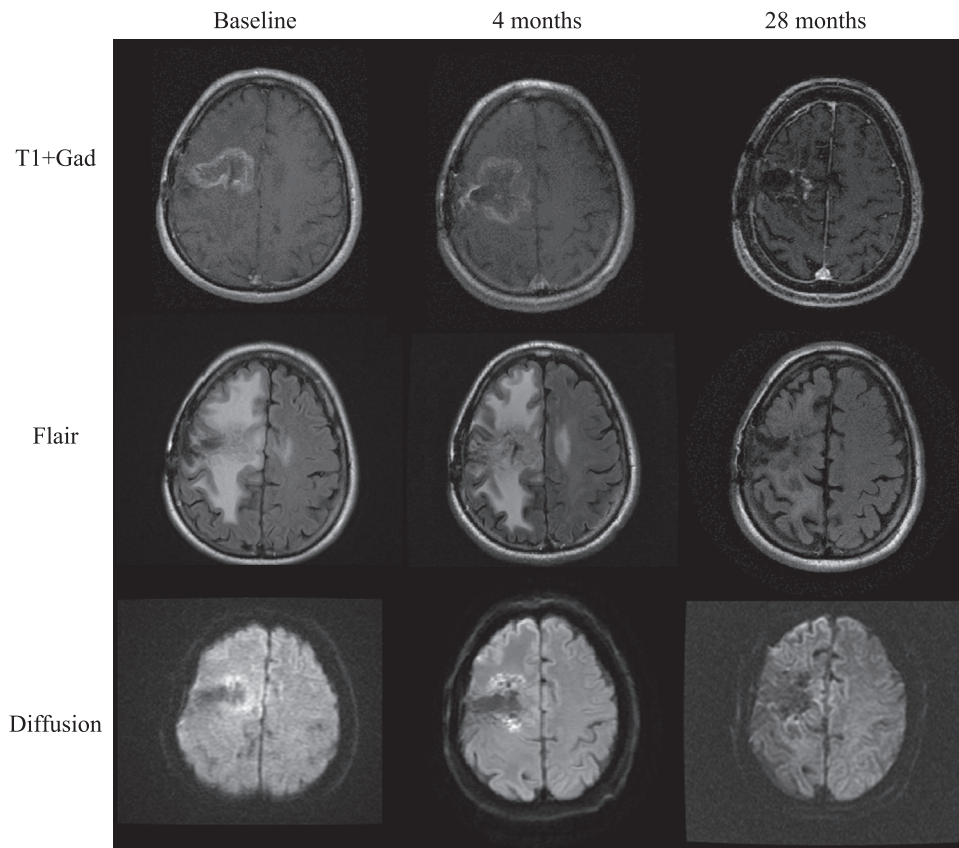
Exemplary T1-weighted images after contrast agent administration with their corresponding FLAIR and Diffusion MRI scans of a heavily pretreated 48-year-old man with secondary GBM. The patient underwent three debulking surgeries, chemo-radiation with temozolomide, and gamma knife boost. The patient’s tumor showed heterozygous deletions of 1p and 19q and was MGMT promoter methylated. The patient was treated with NovoTTF Therapy for 28 months until radiological response was achieved and has been on treatment since (for 45 months so far). Notably, the patient’s tumor grew for the first 8 months on NovoTTF Therapy and only then started to decrease in size. Additional MRI sequences show that while the tumor was growing initially, this was accompanied by an increase in FLAIR signal, but not in diffusion signal.
